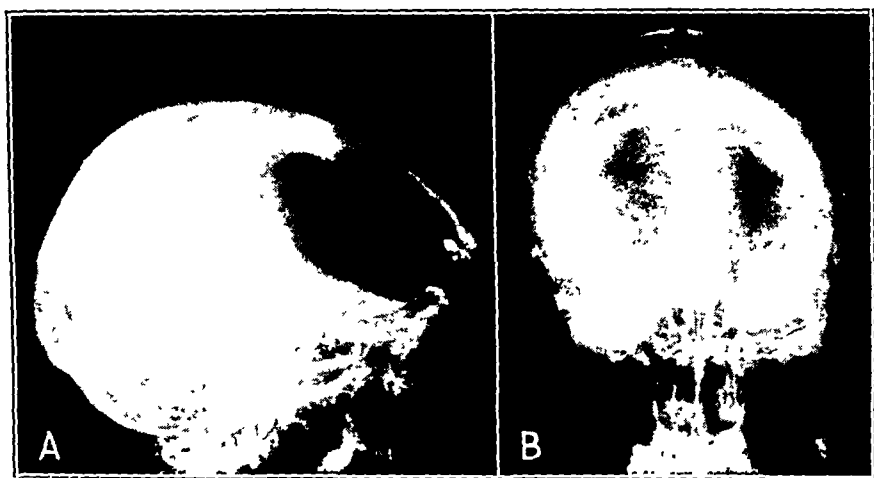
(case 1).—*A*, lateral roentgenogram of the skull taken six weeks after the injury showing huge frontal pneumocephalus. *B*, posteroanterior roentgenogram showing bifrontal pneumocephalus. Note the fistulous openings in the frontal and ethmoid regions.
